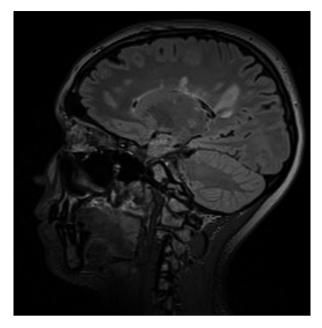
Brain MRI showing multiple gadolinium-enhancing periventricular and juxtacortical lesions
